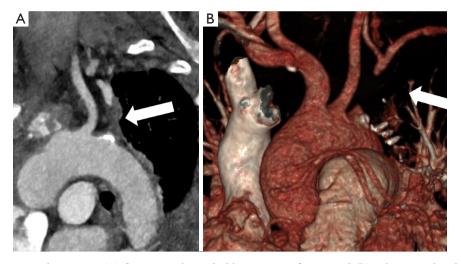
Computed tomography images. (A) Contrast enhanced oblique view reformat and (B) volume rendered 3D-reconstruction of the arterial tree demonstrating proximal occlusion of the left subclavian artery with thrombus. The arrow is pointing towards the proximal subclavian artery occlusion.
